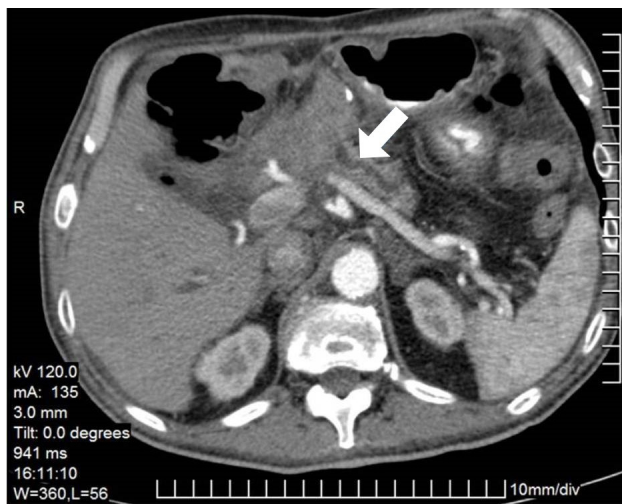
Contrast enhanced CT shows pancreatic duct dilatation of pancreatic remnant (arrow), which was not evident on immediate follow up CT examination post Whipple operation. This is a sign of tumour relapse.
